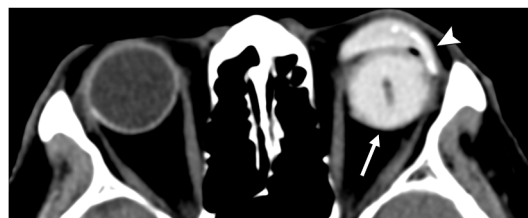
Axial CT showing hyperdense left orbital implant (arrow) and ocular prosthesis (arrowhead).
